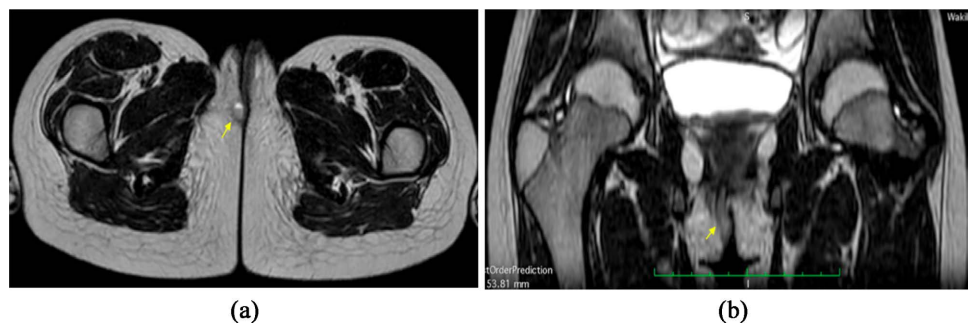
MRI Axial (a) and coronal (b) T2w sequence confirmed the presence of perineal abscess posterior to the right major labrum (arrow).
